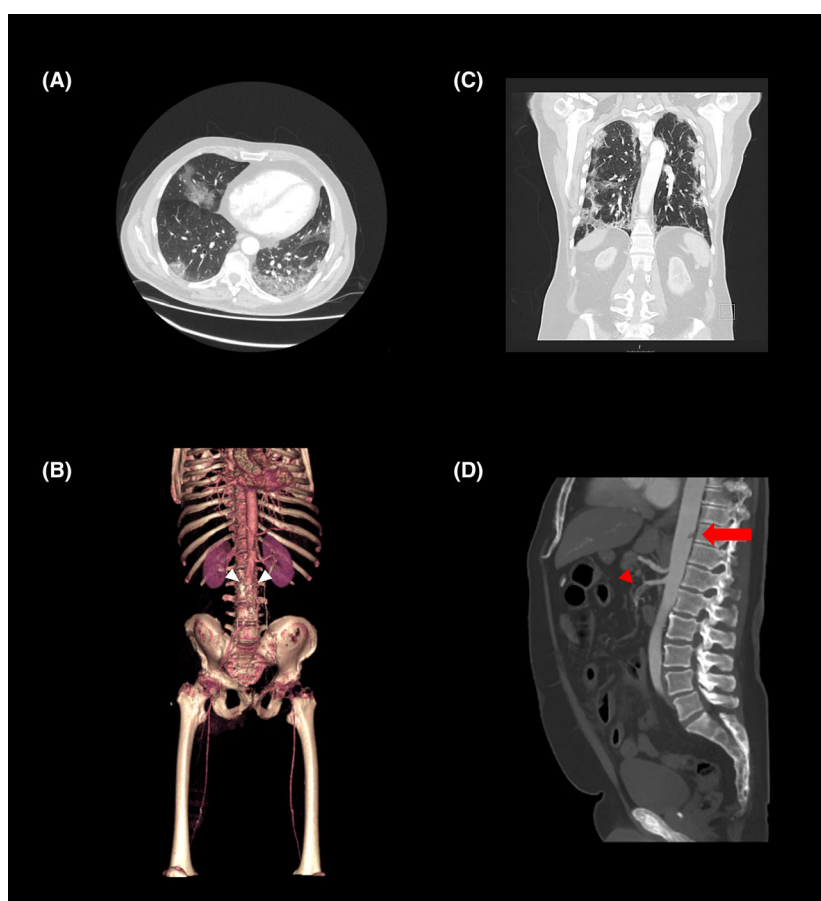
Arterial thrombotic events in patients with Covid-19. A and B: Computerised tomography (CT) of the chest (A) and angiography (B) in a 60-year-old man with cough, fever and leg paralysis. An abrupt occlusion of the infrarenal aorta is evident on angiography (white arrowhead, B). C and D: CT findings in a 75-year-old man with breathlessness and abdominal pain. Intraluminal thrombus in the descending thoracic aorta (red arrow) and superior mesenteric artery (red arrowhead) are indicated.
